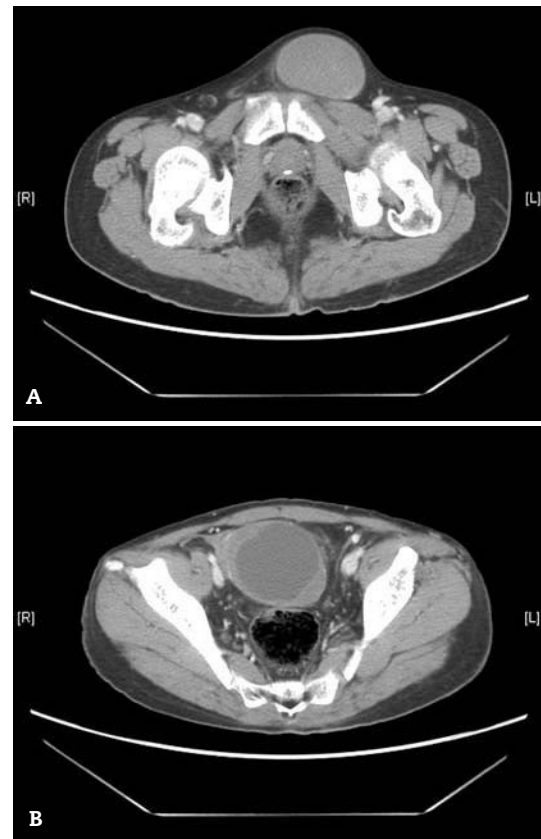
A: Computed tomography image showing the presence of mass in the left groin, compatible with a testis at that level. B: Note the presence of mass at the level of the pelvic cavity.
